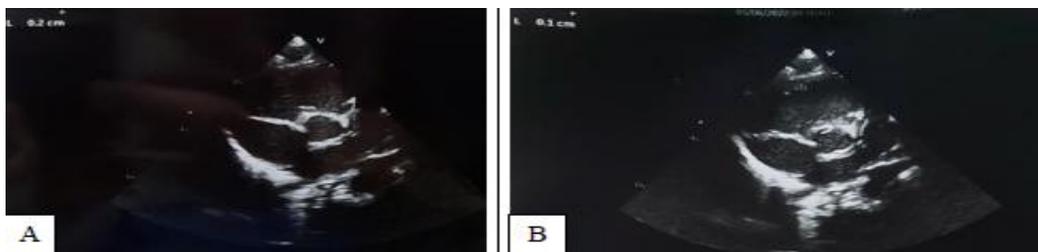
2-D echocardiography showed presence of proximal left coronary artery dilatation, with left coronary artery measuring 0.20cm proximally (A) and 0.10cm distally (B).
